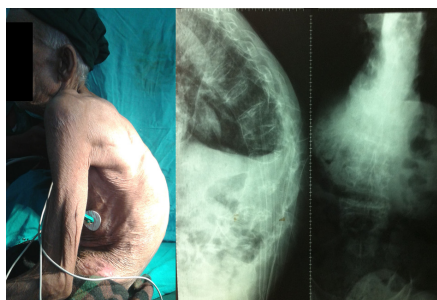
Photograph and radiograph of the second patient with severe kyphosis and mild scoliosis
